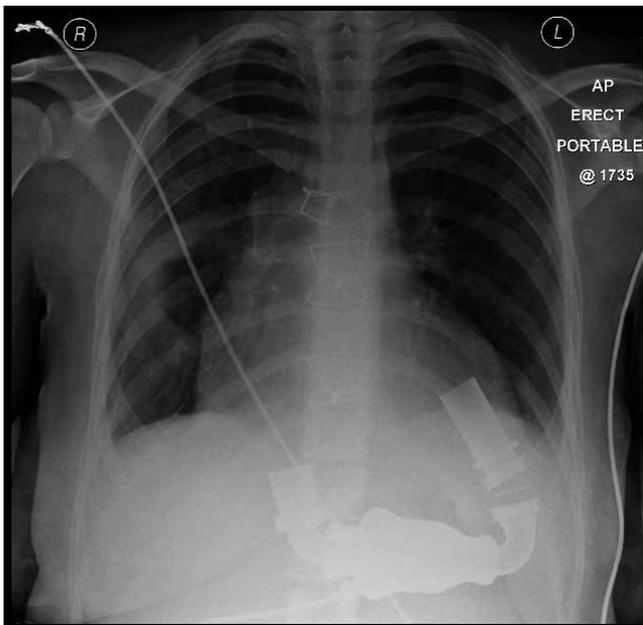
Chest X-ray demonstrating HeartMate II LVAD in situ
